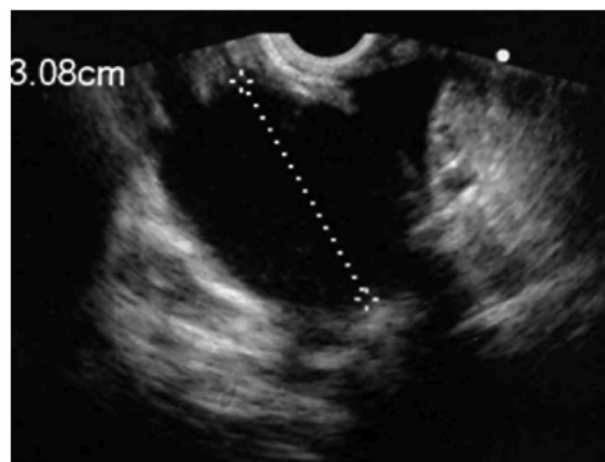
Pseudocyst in the body of the pancreas in endosonography
